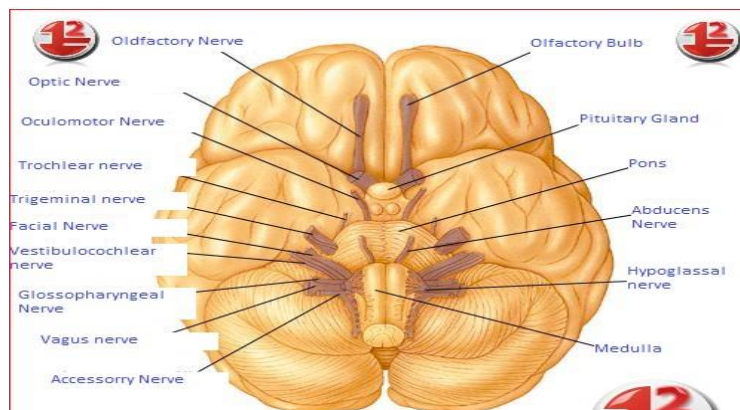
Figure (2_4): Cranial nerves((Radiographic anatomy and physiology)
